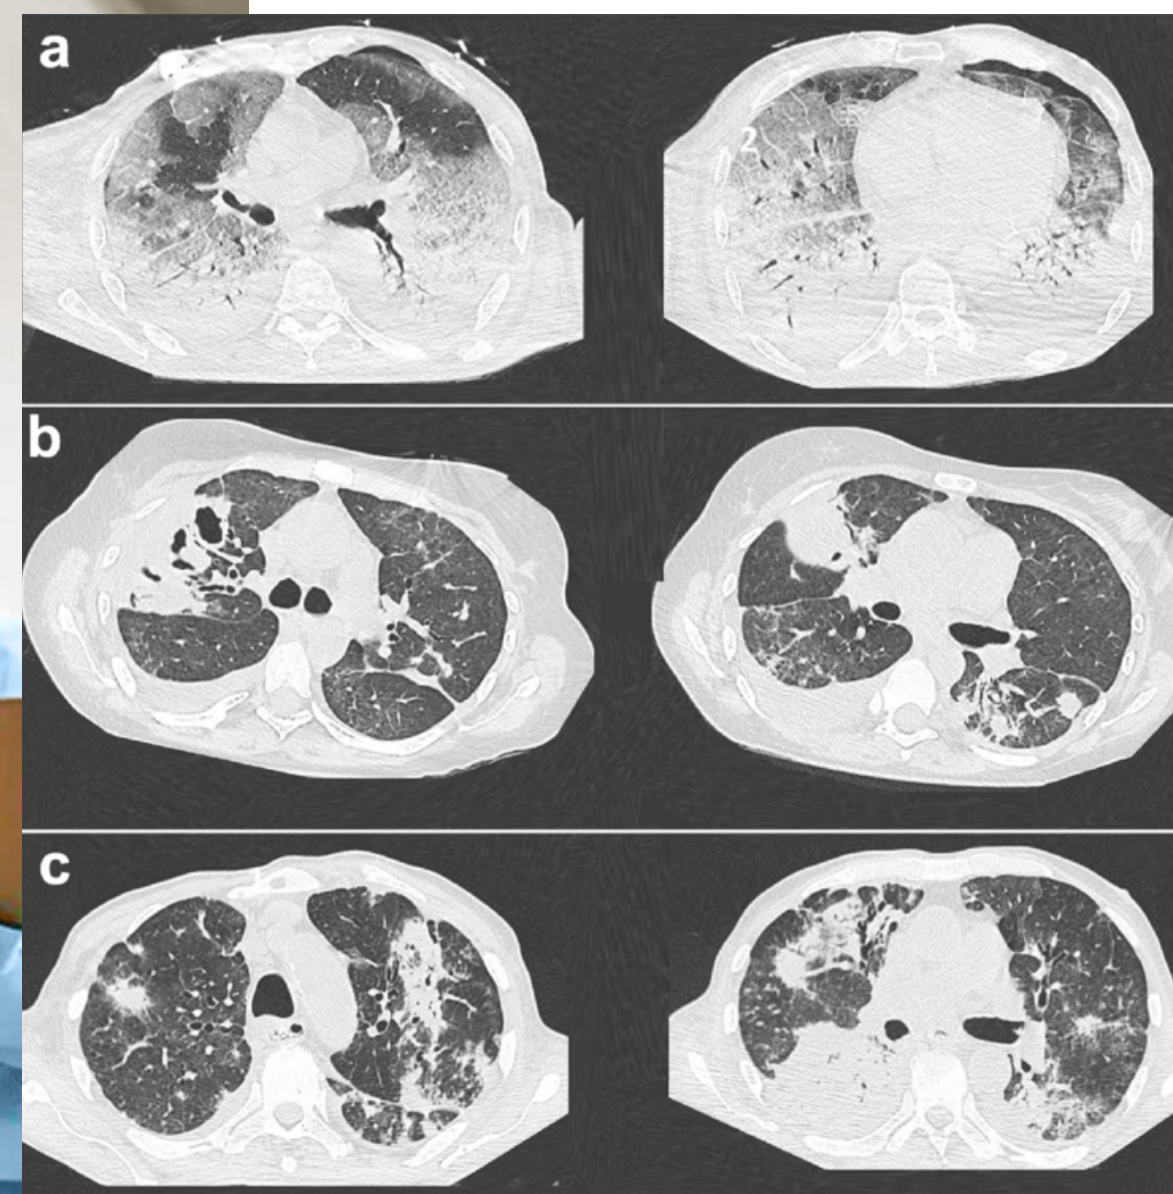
CT scan images in a patient with ARDS
